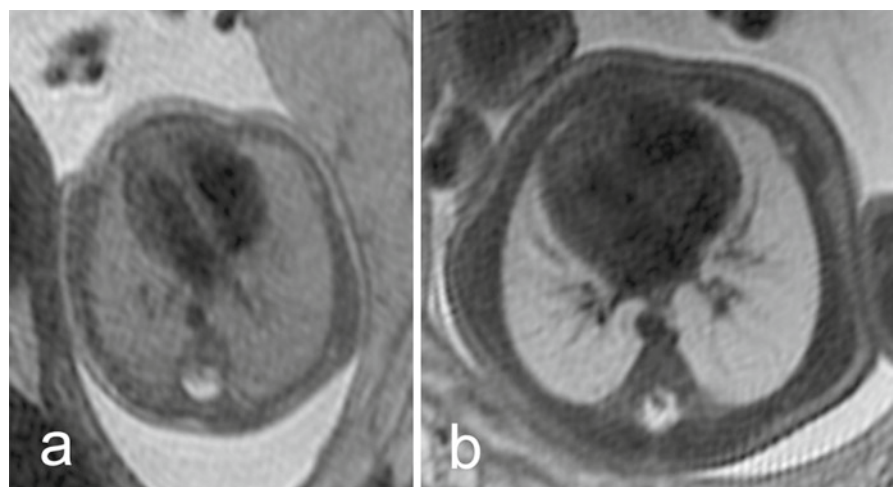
Axial T2-weighted images through the fetal thorax at 23+0 GW (a) and 34+1 GW (b). The interventricular septum and myocardium are seen in (a). The thoracic aorta is seen descending on the left side in both fetuses. (b) The pulmonary veins are clearly depicted
